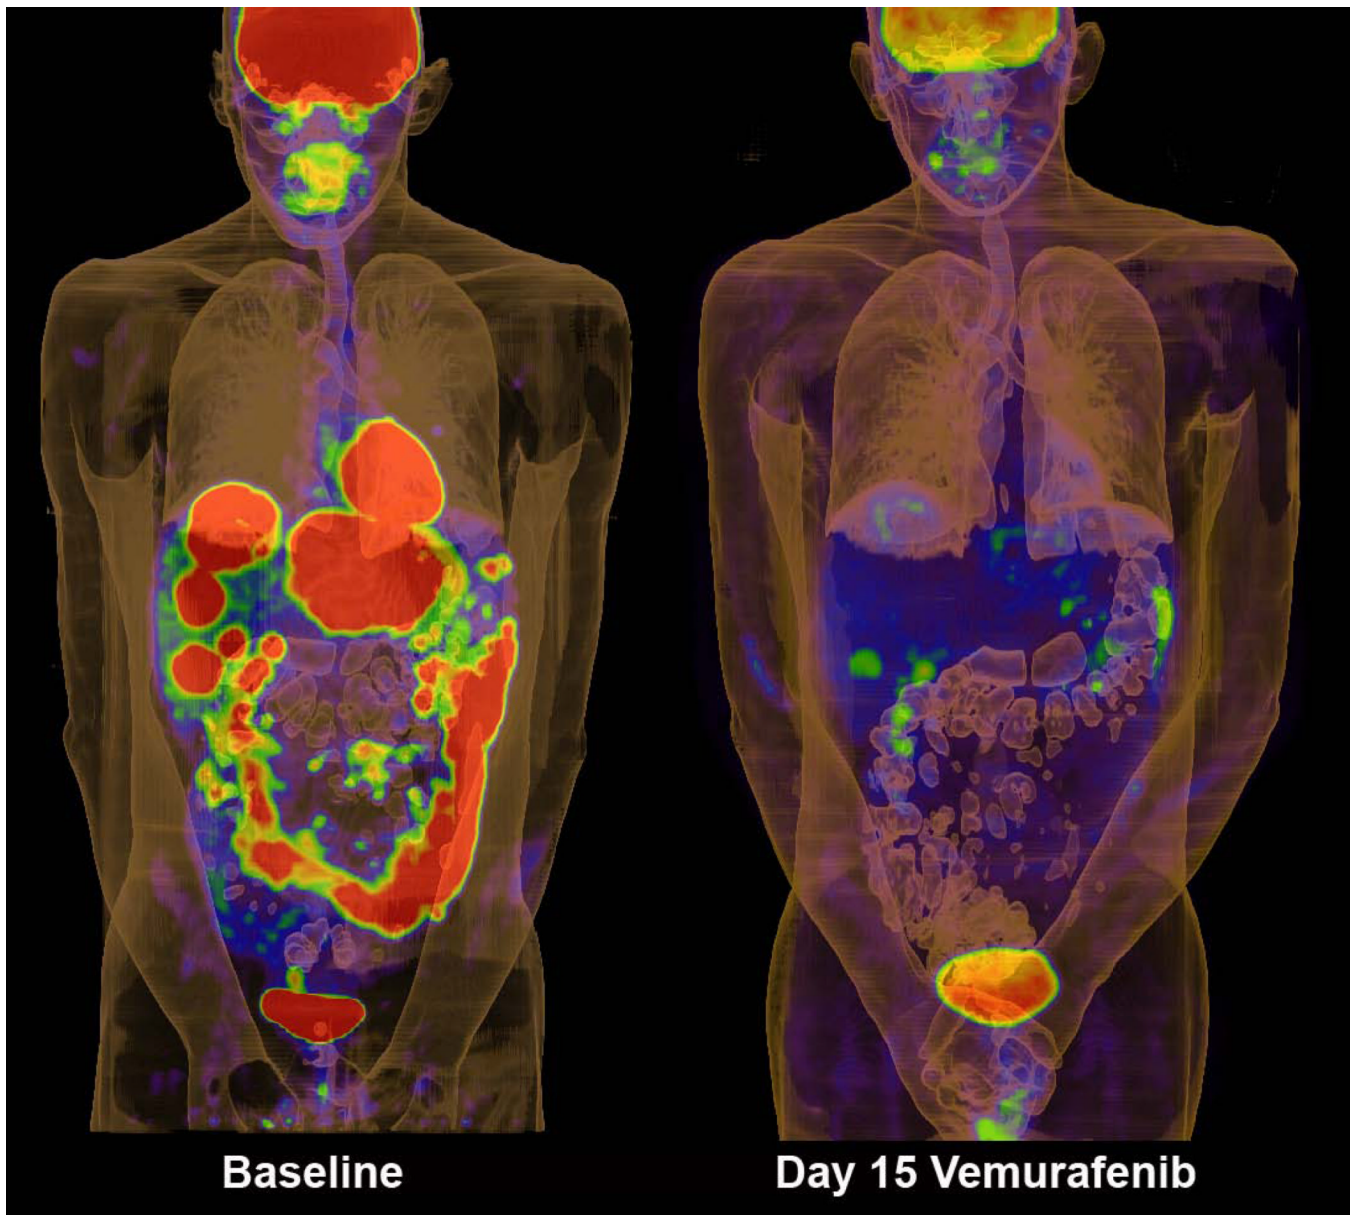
FDG-PET scans of patient on the phase I trial of vemurafenib. Panels show scans of tumor burden at baseline and after 15 days of treatment at 960mg bid.
